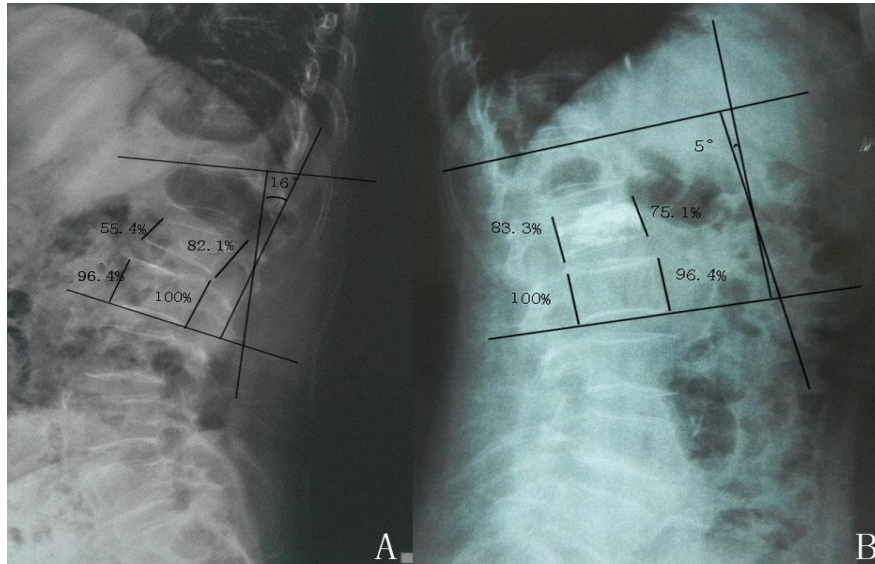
Measurement of vertebral height and kyphotic angle before (A) and after (B) treatment. The posterior height of caudal healthy vertebra which was adjacent to OVCF was measured and transferred as 100% on the radiograph. The kyphotic angle was measured as the angle between the superior endplate at 1 level above the fractured vertebrae and inferior endplate at 1 level below the fractured vertebrae.
